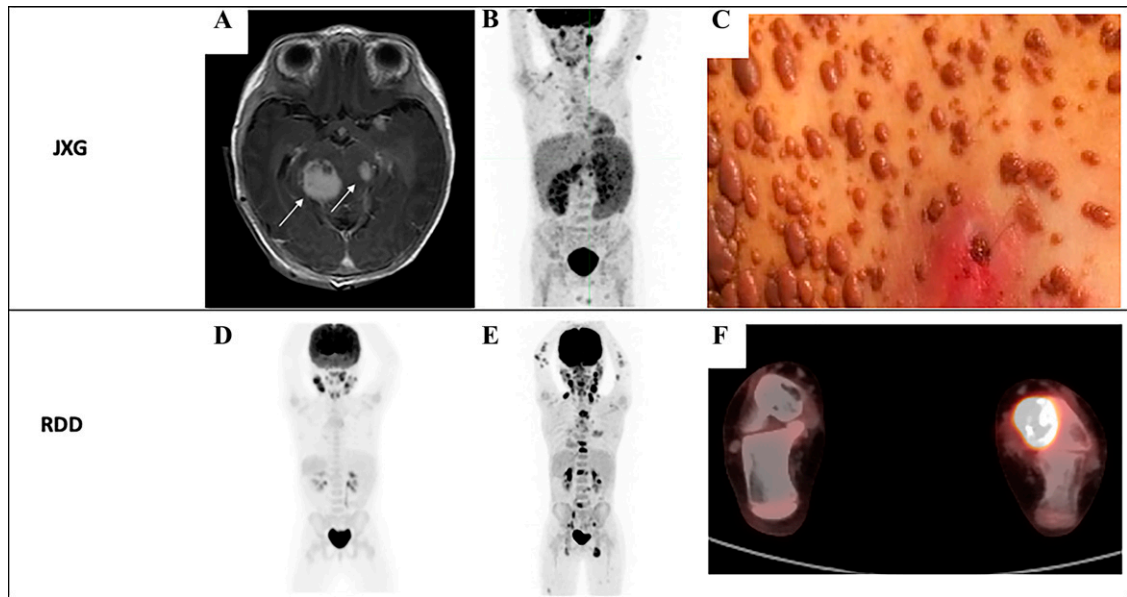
Clinical features of pediatric juvenile xanthogranuloma (JXG) (top) and Rosai-Dorfman disease (RDD) (bottom). A, Brain magnetic resonance image shows JXG brain lesions (arrows). B, Fluorodeoxyglucose positron emission tomography–computed tomography (PET-CT) scan shows a patient with disseminated JXG: cervical and supraclavicular hypermetabolic lymph node and diffuse splenic involvement. C, Photograph of a young woman with severe JXG skin lesions. PET-CT scans show classic RDD with significant but limited cervical lymphadenopathy (D), more disseminated RDD with lymphadenopathy in several lymph node regions (E), and osseous RDD lesion in the left medial malleolus and talus (F).
